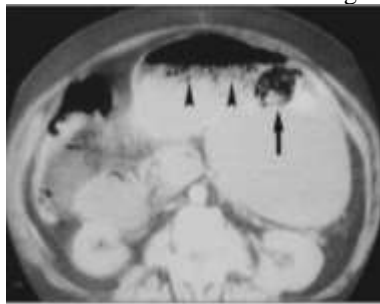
CT scan attained without oral or IV contrast material shows an inhomogeneous mass with a mottled gas pattern (arrow) floating into the distended stomach. This appearance differs from that of ingested food (arrowheads).
